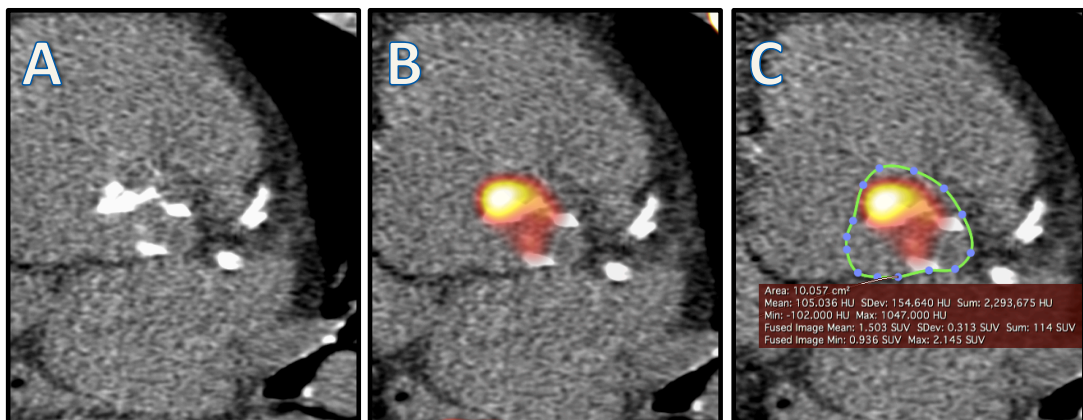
Creation of planar images of the aortic valve using non-contrast computed tomography.
